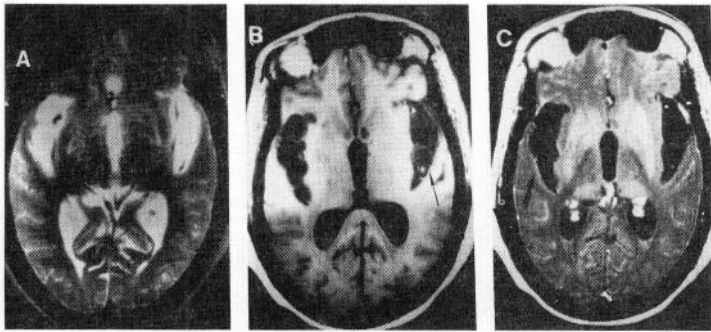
T2 hypointense cysticercosis lesions. T2-weighted axial image (a) through the level of midbrain/pons shows evidence of T2 hypointense areas in the cerebellar hemispheres, bilateral temporal lobes, and in the left crus region. A hyperintense lesion is also seen in the right temporal lobe. On MTT1-weighted image (b), visualization of these lesions is difficult and the MT ratio from the T2 hypointense areas was more than 35%. Only T2 hyperintense lesion is seen on T1-weighted image (c) and the rest of the lesions are isointense and not visible.
